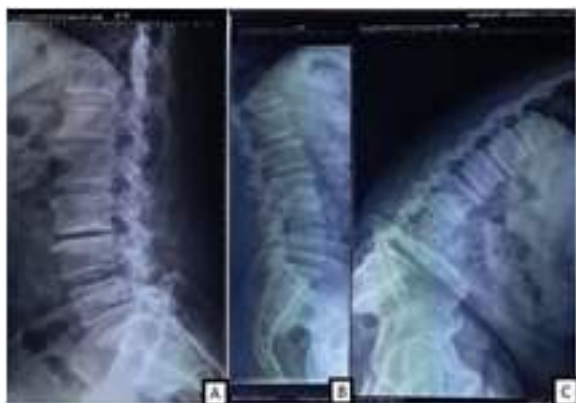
The conventional lateral radiograph of one of the study subjects (A) shows osteophytes and there is no spondylolisthesis. The extension lateral radiograph (B) demonstrates no spondylolisthesis, but the flexion lateral radiograph (C) reveals anterolisthesis at the level of L4-5.
